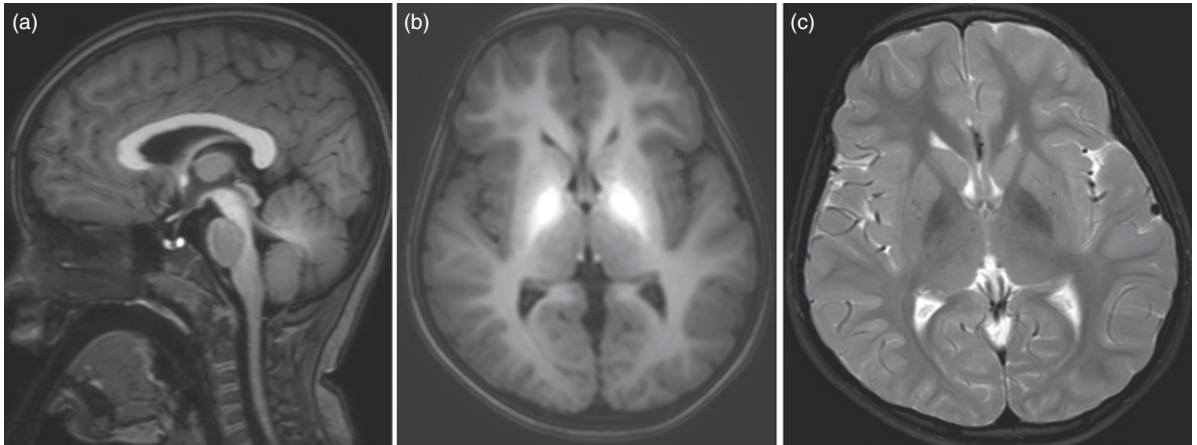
MRI brain appearances in SLC39A14 deficiency. Generalized T1 hyperintensity of (a) the white matter, including the dorsal pons and cerebellum, and the pituitary gland, on sagittal images; and (b) the cerebral white matter, globus pallidus, and striatum, on transaxial images, can be observed. (c) Hypointensity of the globus pallidus is also evident on T2-weighted imaging. From: Tuschl K, Meyer E, Valdivia LE et al Mutations in SLC39A14 disrupt manganese homeostasis and cause childhood-onset parkinsonism-dystonia. *Nat Commun.* 2016 May 27;7:11601
